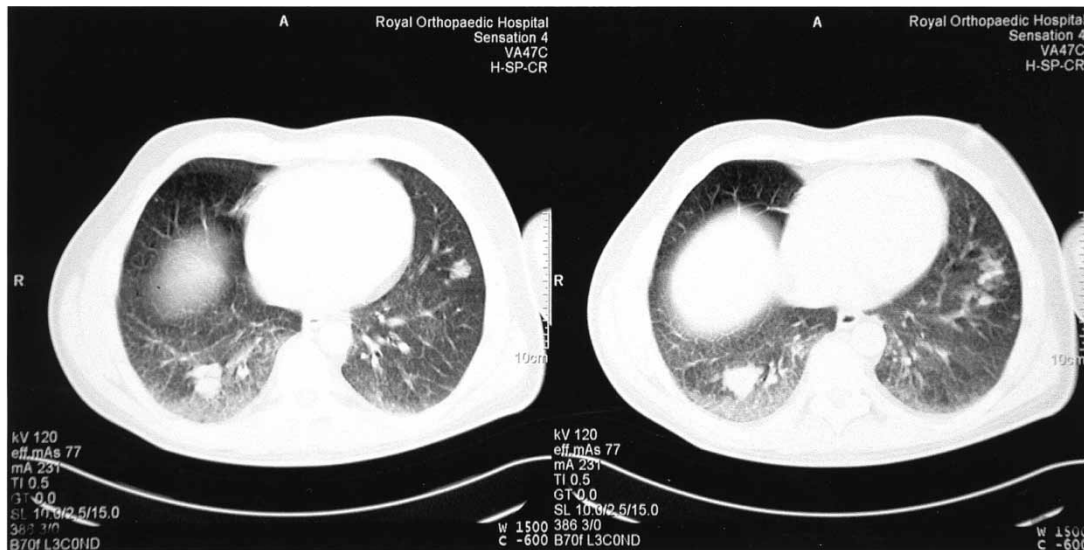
Computed tomography of the chest. This shows lung window images of the bases showing irregular nodular lesions measuring up to 2 cm in diameter, suggestive of pulmonary metastases. Chondrosarcoma usually produces macro nodular metastases.
